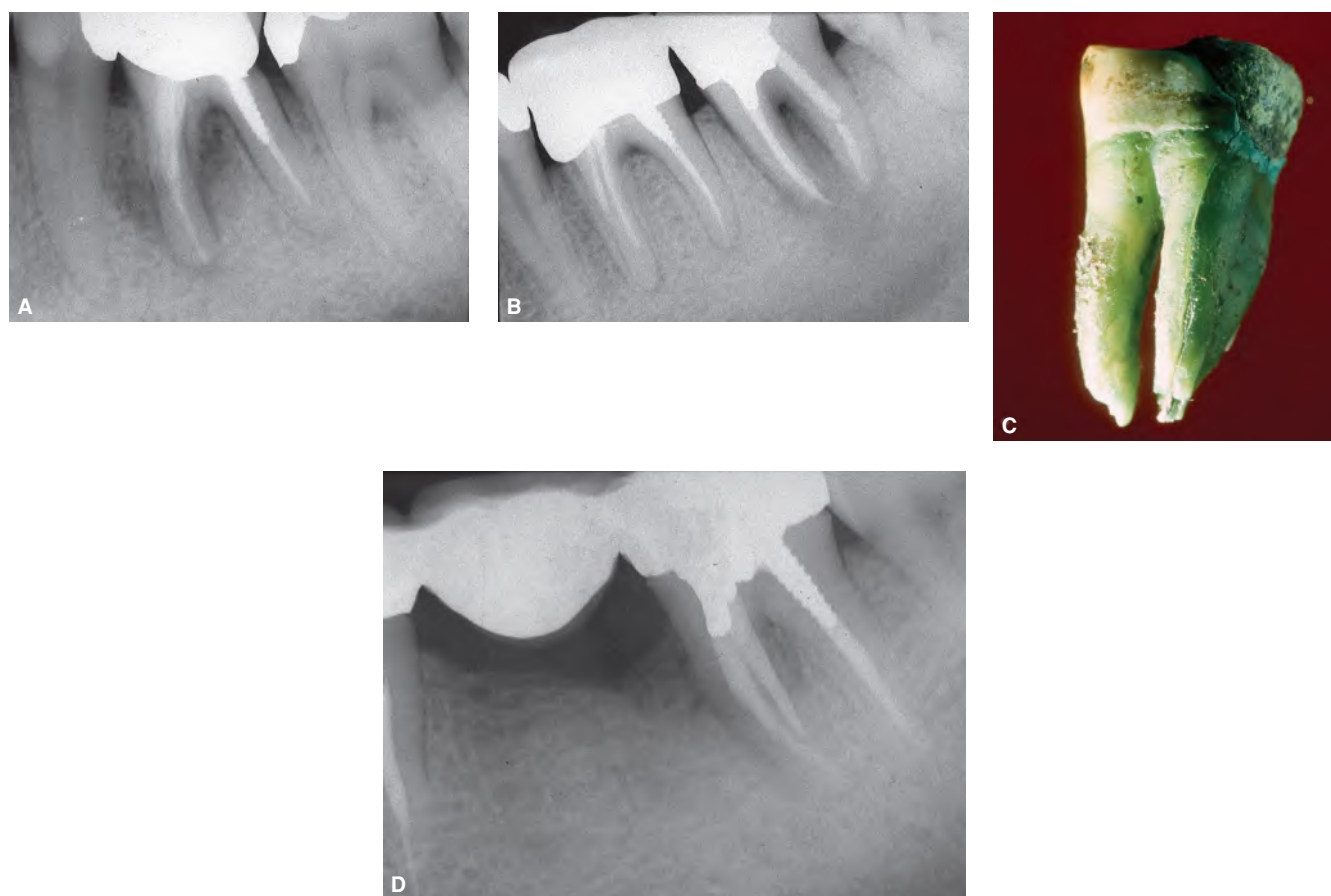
Typical bony periradicular radiolucencies around mesial roots of mandibular molars. A. Lateral radiolucency on the mesial aspect of the root and at the bifurcation area of a mandibular first molar. B. Periapical and bifurcation radiolucency around a second mandibular molar. C. Extracted tooth (B) shows the fracture line at the buccal aspect of the mesial root. D. Angular and bifurcation radiolucency.
